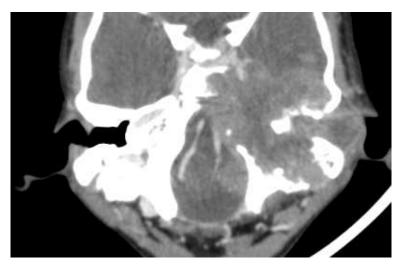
Contrast enhanced axial CT image showing enhancing soft tissue mass in the region of left temporal bone causing its osseos destruction and loss of normal anatomical landmarks. FNAC from the lesion came out to be rhabdomyosarcoma
